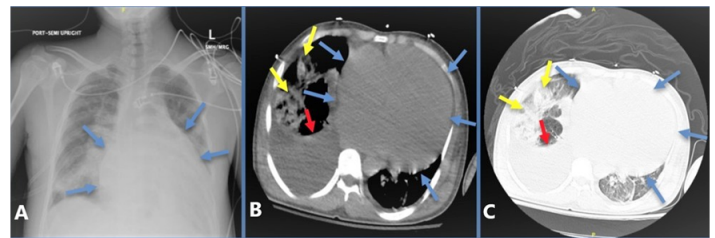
Plain radiography and axial slide of a chest CT-scan without contrast (mediastinal and lung windows, respectively), demonstrating severe cardiomegaly (blue arrows), pulmonary consolidations (yellow arrows), and a large pleural effusion (red arrows). (Panel A) Chest radiography demonstrating severe cardiomegaly (blue arrows). (Panel B) Mediastinal window of CT-chest without contrast revealing severe cardiomegaly (blue arrows), right-sided pleural effusions (red arrows), and pulmonary consolidations (yellow arrows). (Panel C) Lung window of a CT of the chest without contrast revealing severe cardiomegaly (blue arrows), right-sided pleural effusion (red arrow), and pulmonary consolidations (yellow arrows).
